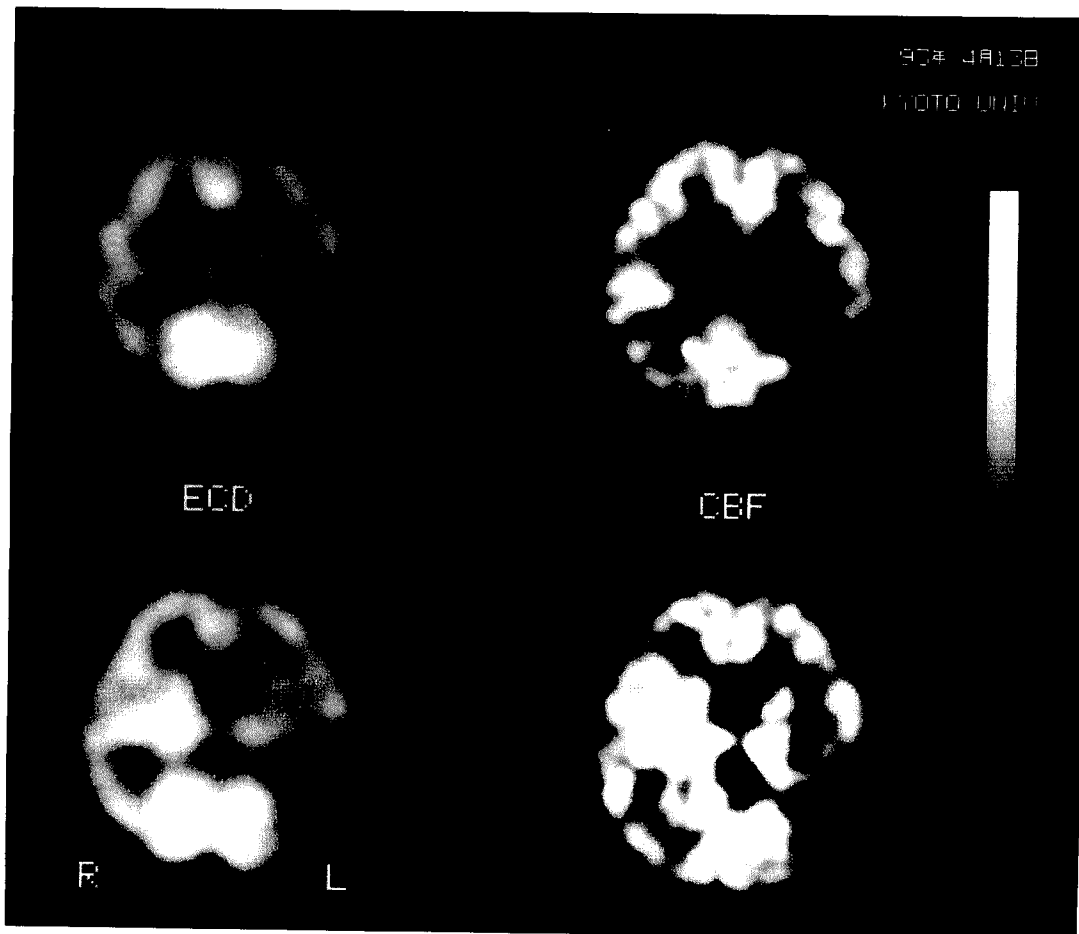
^{99m}Tc -Bicisate (ECD) single photon emission computed tomography (SPECT) and CBF positron emission tomography (PET) images in a case with chronic cerebral infarction. Both SPECT and PET showed a similar distribution pattern: decreased CBF in the left temporooccipital region.
